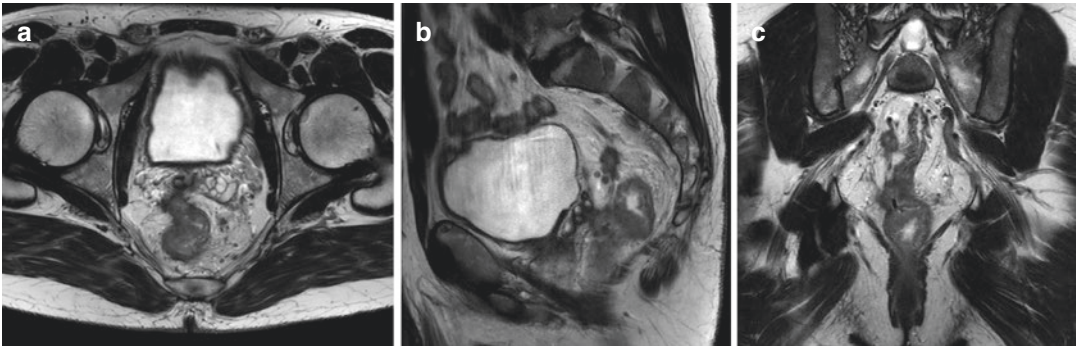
Axial (a), sagittal (b), and coronal (c) views of an MRI of a locally advanced rectal cancer infiltrating the right seminal vesicle
